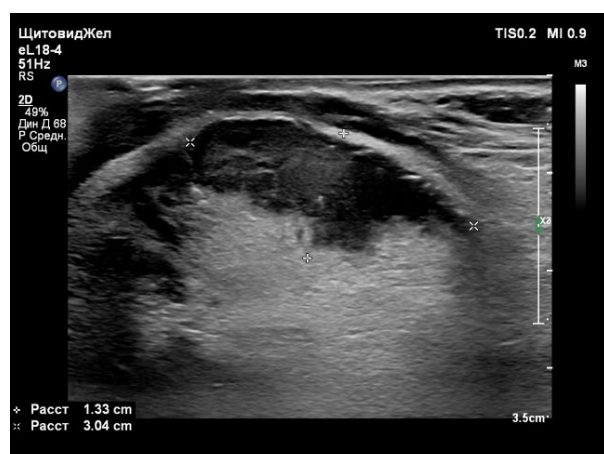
B-mode ultrasound image of a tongue tumor: hypoechoic neoplasm, irregular shape, uneven, indistinct contours, heterogeneous echostructure, 1.3 × 3.0 cm in size.
